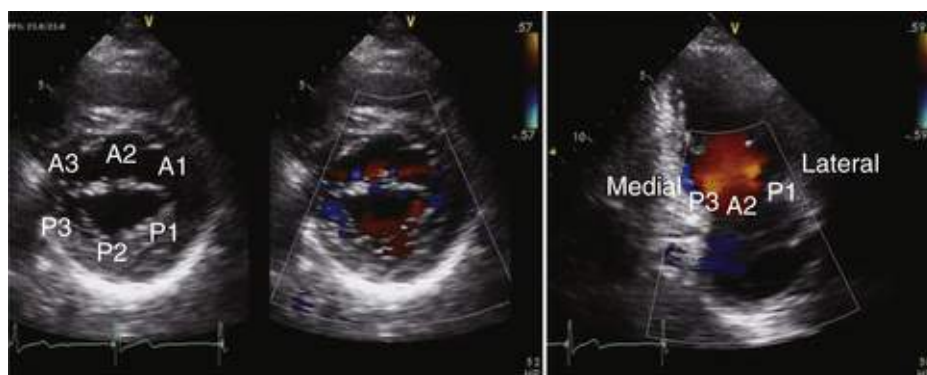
When examining the mitral valve echocardiographically, it is crucial to obtain anatomically oriented images that localize the origin of the regurgitant jet, particularly along the medial-lateral extent of the commissural closure line. The parasternal short-axis view (left) and apical two-chamber view (right) both allow this delineation. Localizing the proximal convergence zone in these views can be particularly helpful in assessing the mechanism.
